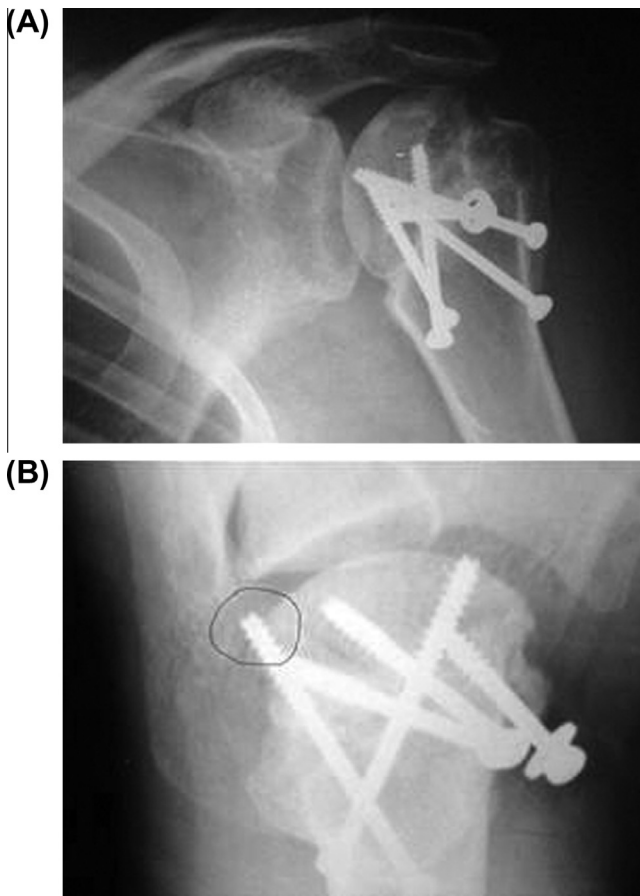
(A) Radiograph of left shoulder (anterior–posterior view) following internal fixation of fracture at the surgical neck, fixed by metal screws. All the screw tips are seen inside the boundaries of the cortical, which is the outer dense bone boundary, and subchondral bone, a layer of dense bone tissue that is situated below and supports the cartilage cover of an articular surface of a head of humerus, i.e. long bone of arm. (B) Radiograph of the left shoulder of the same patient (axillary view). The tip of one of the screws (marked) is situated out of the boundary of the articular surface of the humeral head. This penetration of the fixing screw is obscured on the standard anteroposterior view shown in radiograph (A).
